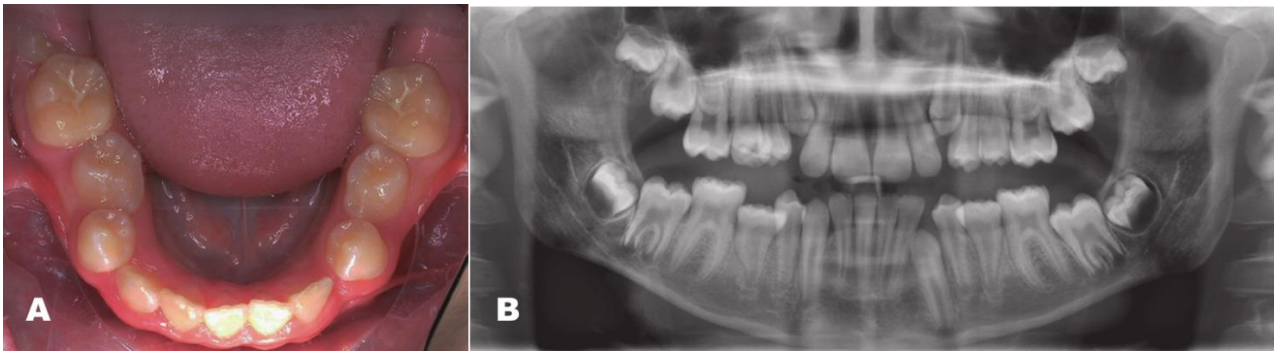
A to C: Mulberry molars in the (A) Maxillary arch; (B) mandibular arch; and (C) orthopantomogram.
